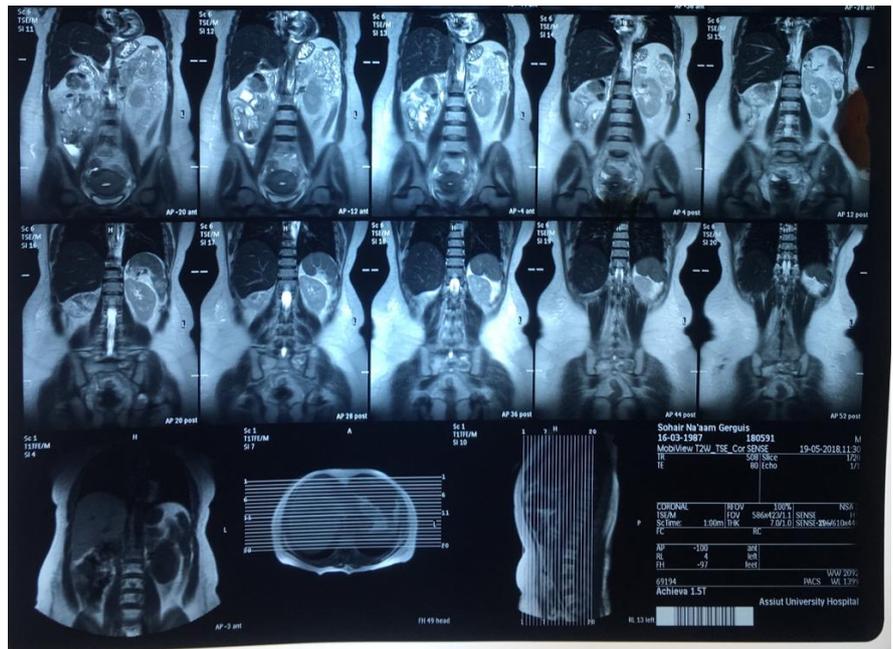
Whole body MRI showing renal mass at lower pole with pathology of clear RCC with hepatic and bony metastasis.
